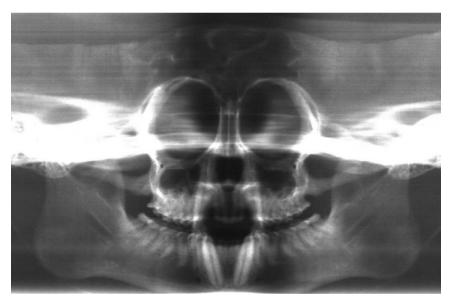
Panoramic radiograph of the maxilla and mandible in a male *Cebus apella (Linnaeus, 1758).*
